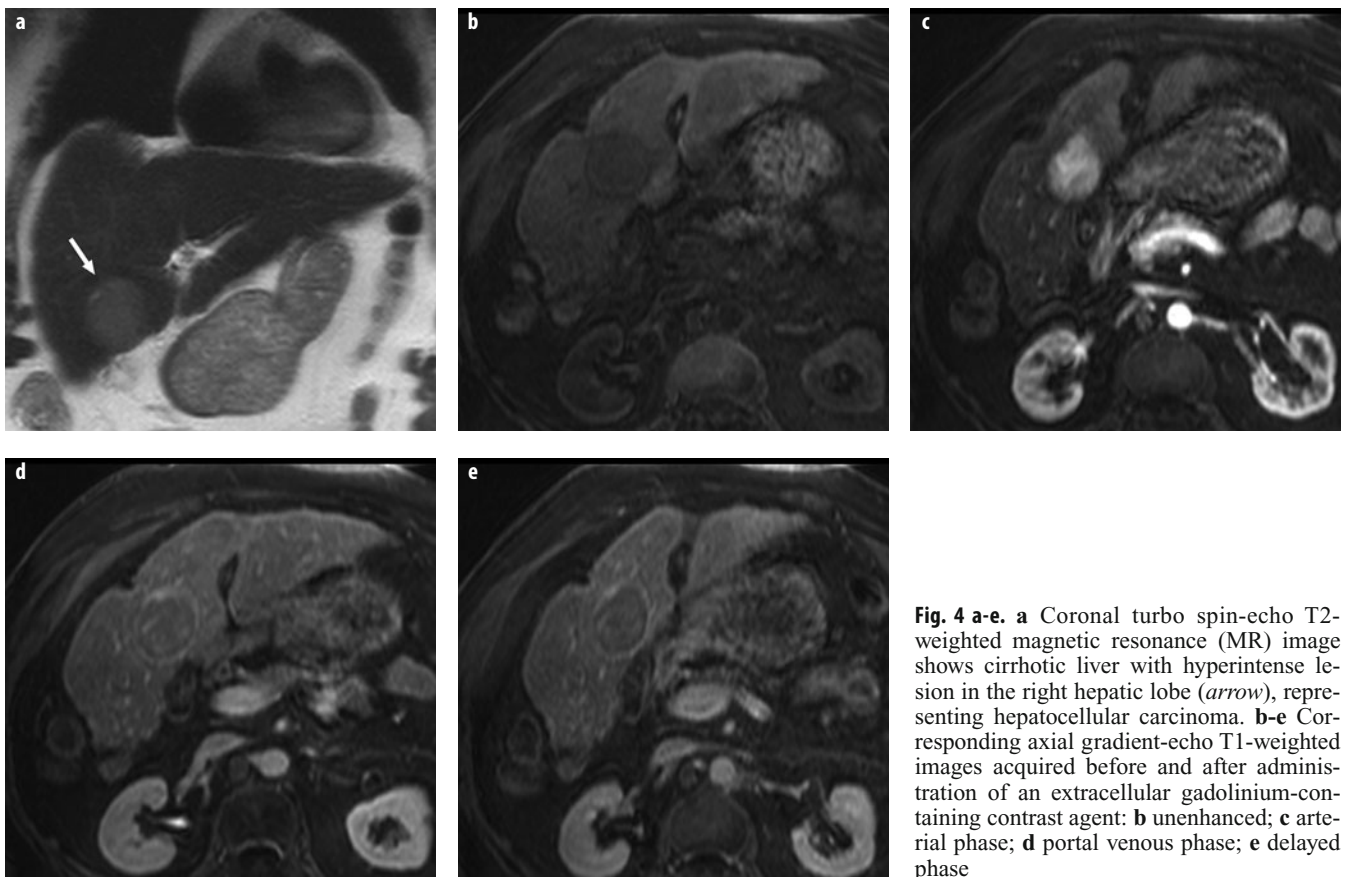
a-e. a Coronal turbo spin-echo T2-weighted magnetic resonance (MR) image shows cirrhotic liver with hyperintense lesion in the right hepatic lobe (*arrow*), representing hepatocellular carcinoma. b-e Corresponding axial gradient-echo T1-weighted images acquired before and after administration of an extracellular gadolinium-containing contrast agent: b unenhanced; c arterial phase; d portal venous phase; e delayed phase
